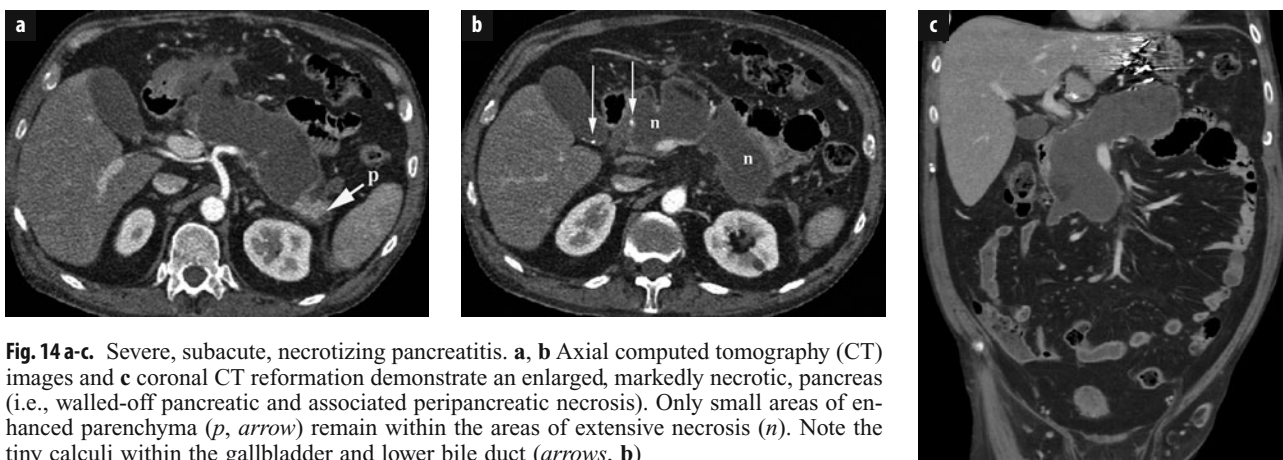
a-c. Severe, subacute, necrotizing pancreatitis. a, b Axial computed tomography (CT) images and c coronal CT reformation demonstrate an enlarged, markedly necrotic, pancreas (i.e., walled-off pancreatic and associated peripancreatic necrosis). Only small areas of enhanced parenchyma (*p*, arrow) remain within the areas of extensive necrosis (*n*). Note the tiny calculi within the gallbladder and lower bile duct (arrows, b)
